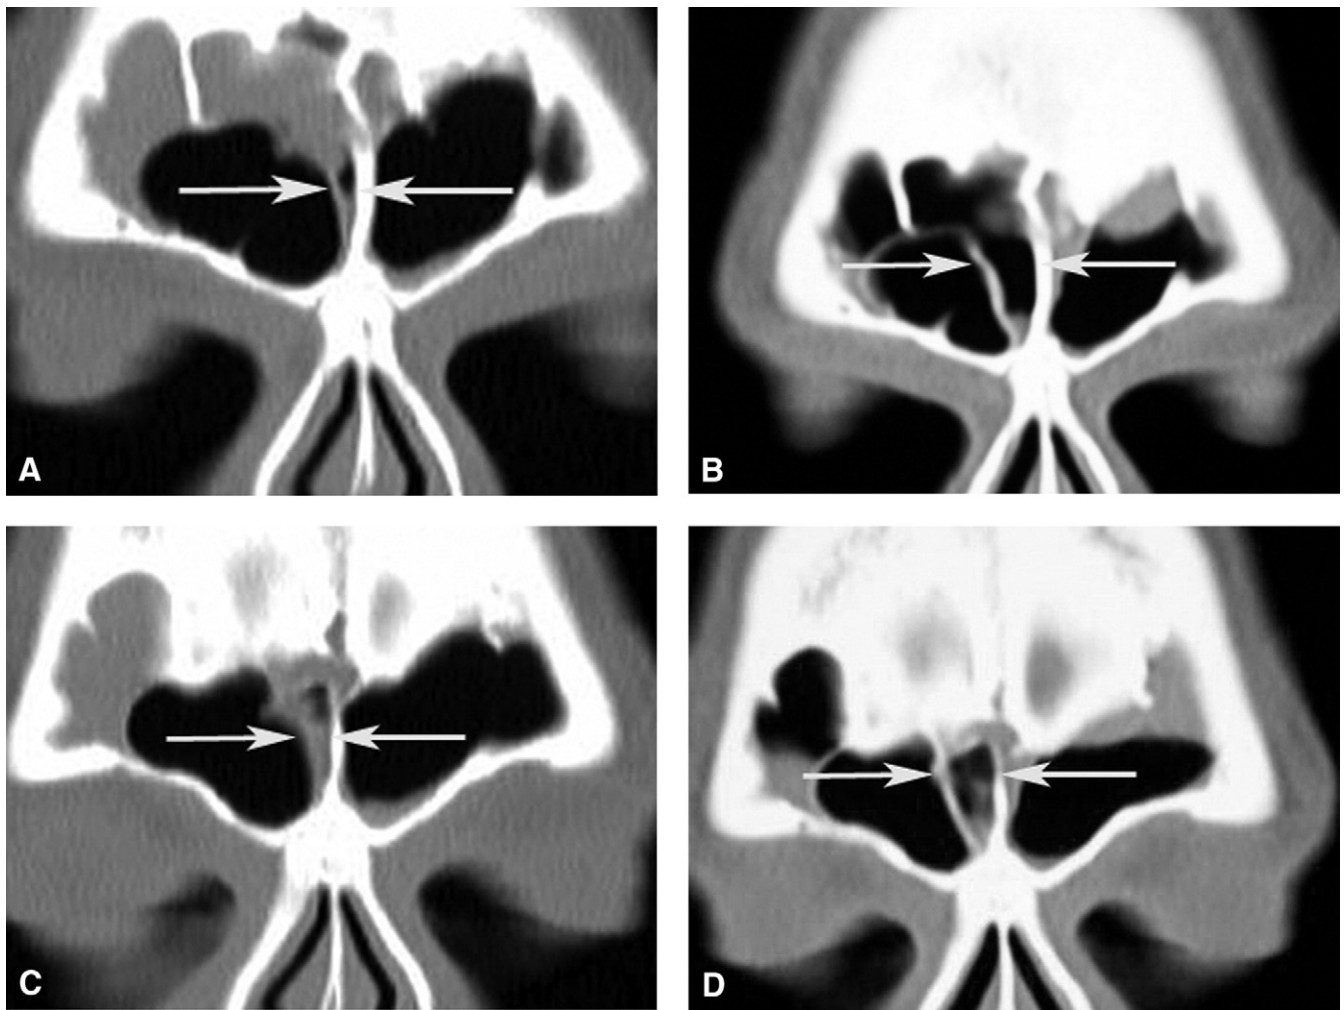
(A) The right frontal sinus with massive type IV frontal cell obstructing frontal sinus; see arrows (preoperative CT). (B) Six-month postoperative CT scan comparable to 5A. The type IV frontal cell medial wall has been moved laterally away from the interfrontal sinus septum. (C) Right frontal sinus drainage pathway; see arrows (preoperative CT scan). (D) Six-month postoperative CT scan comparable to 5C. Images B and D, 2.5 mm apart, show that the medial frontal cell wall has been moved laterally over several millimeters (anterior to posterior), which has opened the frontal sinus drainage pathway.
